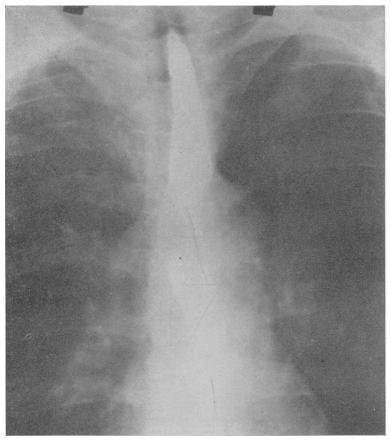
Original X-ray showing defect level of 2d rib anteriorly.
